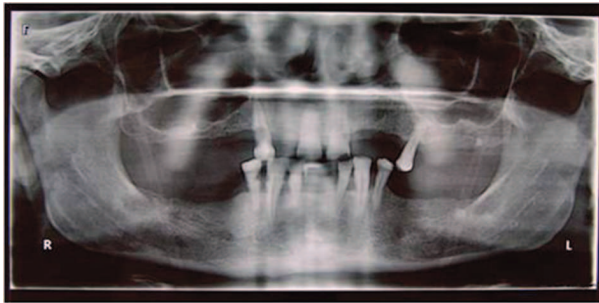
A panoramic X-ray of the initial situation
